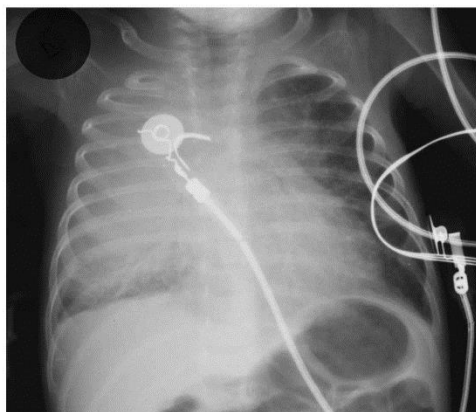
Chest radiograph of the sentinel case on admission to the intensive care unit (ICU), showing widespread alveolar opacification of the right lung, extensive hilar adenopathy and airway compression
